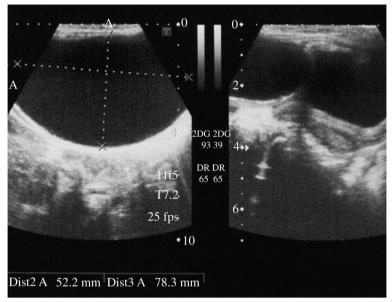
Ultrasound which shows an ovarian torsion.
